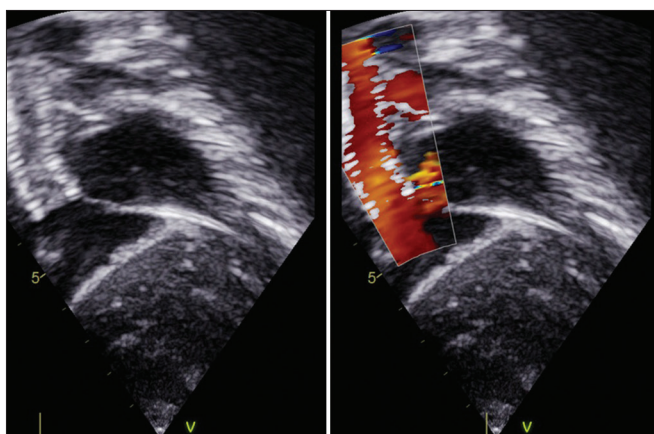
Echocardiography showing the stent in proper position with unobstructed flow through the stent
